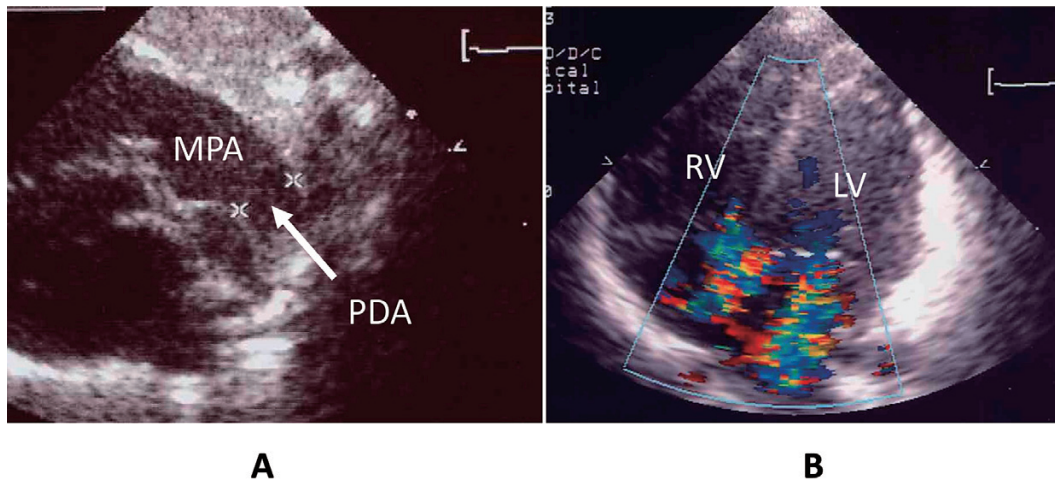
A large PDA (A), mitral regurgitation and tricuspid regurgitation (B) were diagnosed at 5 days of age by echocardiography
